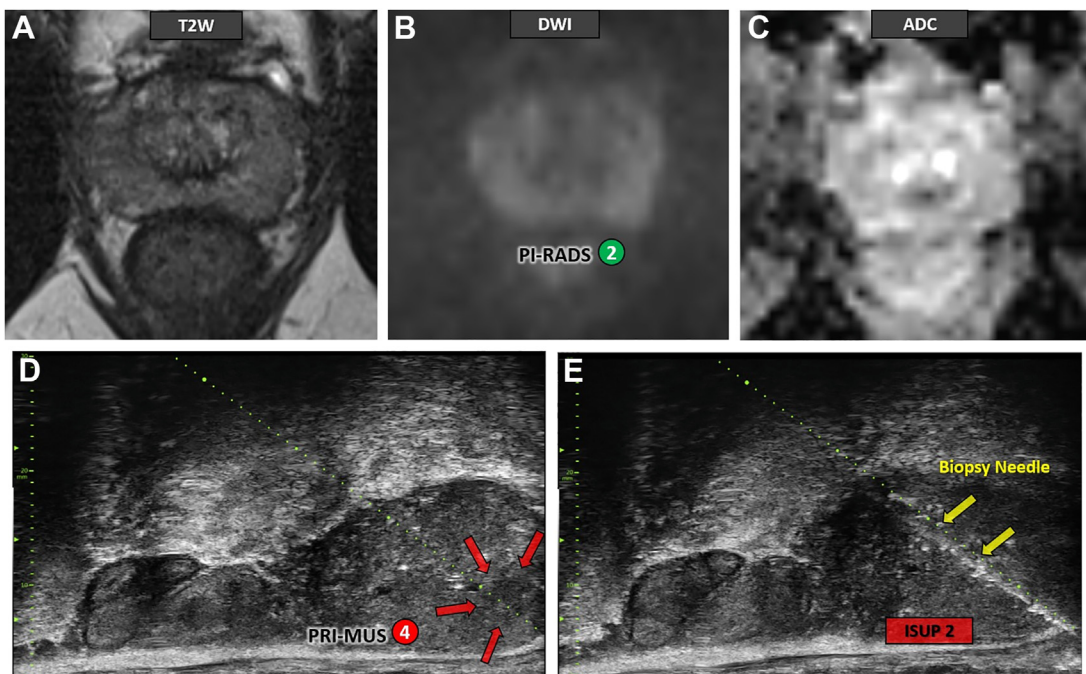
Images in a 49-year-old man with prostate-specific antigen level of 8.26 ng/mL. Multiparametric MRI scans (T2-weighted [A], diffusion-weighted imaging [B] and ADC map [C]) did not show any suspicious lesion (PI-RADS 2). MicroUS scan (D) showed a 6mm-hypoechoic lesion with smudgy pattern (PRI-MUS 4) in the left midgland peripheral zone (red arrows). Targeted biopsy revealed grade group 2 disease (E). PI-RADS, Prostate Imaging Reporting and Data System; PRI-MUS, Prostate Risk Identification Using Micro-Ultrasound.
